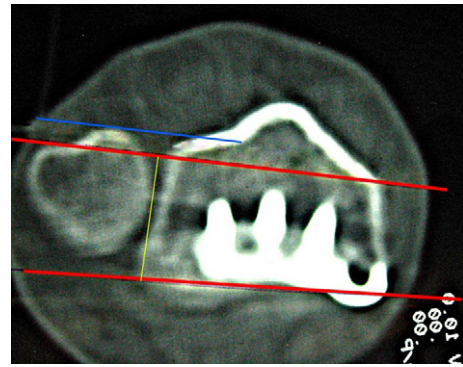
A normal postoperative CT-scan.
